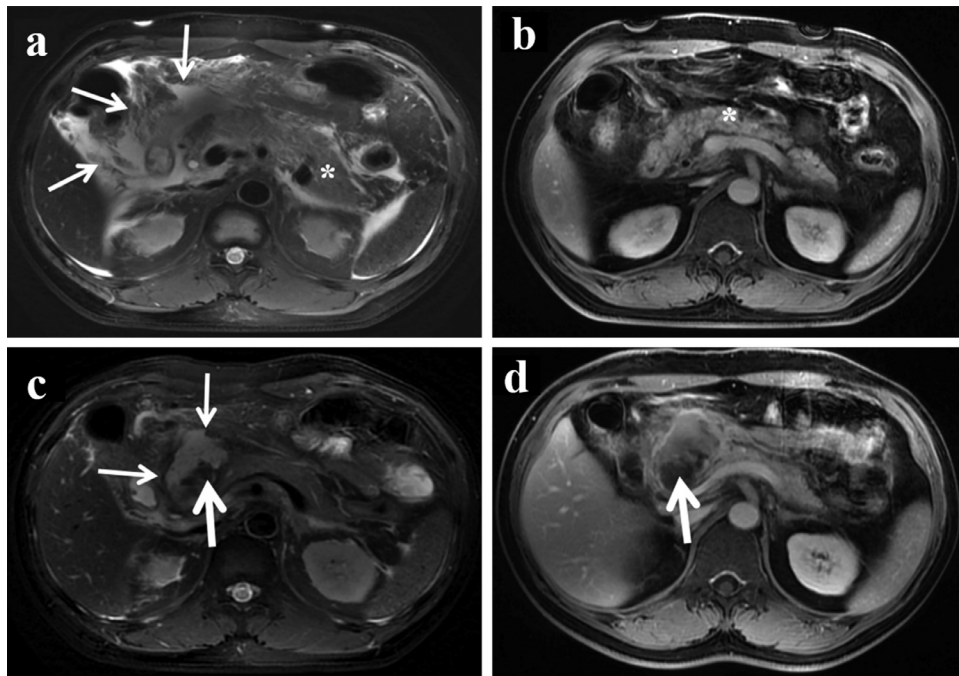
Combined necrosis in a 46-year-old man. (a–b) Axial fat-saturated T2-weighted MR images on the second day of onset show an irregular, homogeneous collection around the head of the pancreas and hepatoduodenal ligament (white arrow) and a normal-appearing pancreatic parenchyma (*). (c–d) Axial fat-saturated T2-weighted MR images obtained 2+ months after discharge reveal the evolution of the homogeneous extrapancreatic collection into well-defined walled-off heterogeneous pancreatic-peripancreatic collections involving the head and neck of the pancreas, with a fluid component that appears hyperintense (white arrow) and necrotic nonliquefied material that appears hypointense (thick white arrows). Axial contrast-enhanced T1-weighted imaging shows no enhancement in the necrotic tissue (thick white arrows), with an enhanced wall surrounding the walled-off necrosis (WON) (white arrowhead).
